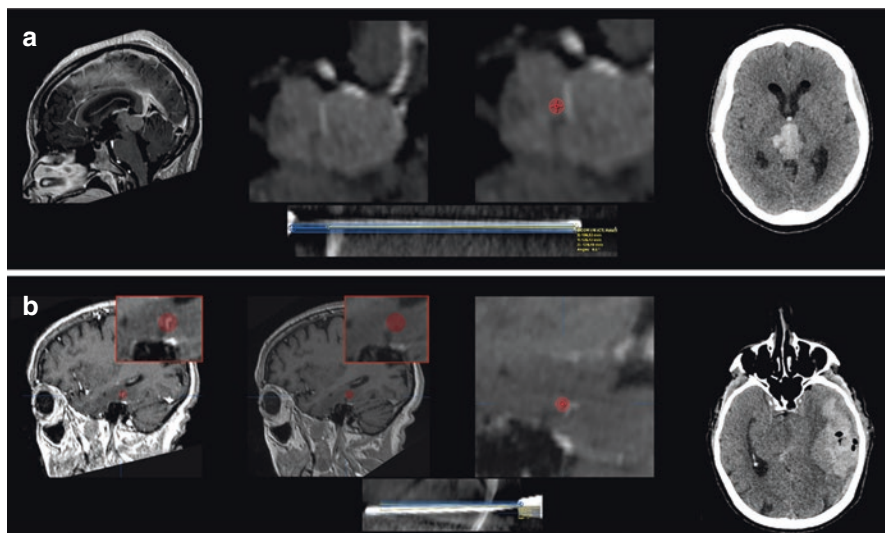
Two cases of robot-assisted biopsies enduring complications. (a) From left to right, upper line: sagittal slice of preoperative 3DT1 with gadolinium enhancement MRI of a 30-year-old woman suffering from a pineal tumor, close-up on the tumoral vessel, co-registration of preoperative MRI and intraoperative O-Arm series showing a good overlap of planned trajectory (angular error: 0.5° , target error: 0.3 mm), close-up on the vascular conflict, postoperative CT scan acquisition showing the intratumoral bleeding. (b) From left to right, lower line: sagittal slice of first preoperative 3DT1 with gadolinium enhancement MRI of a 83-year-old woman suffering from a left temporo-mesial tumor, sagittal slice of second preoperative 3DT1 with gadolinium enhancement MRI, co-registration of preoperative MRI and intraoperative O-Arm series showing a good respect of planned trajectory (angular error: 2.6° , target error: 2.0 mm), close-up on the vascular conflict, postoperative CT scan acquisition showing the intraparenchymal and the subdural hematoma
